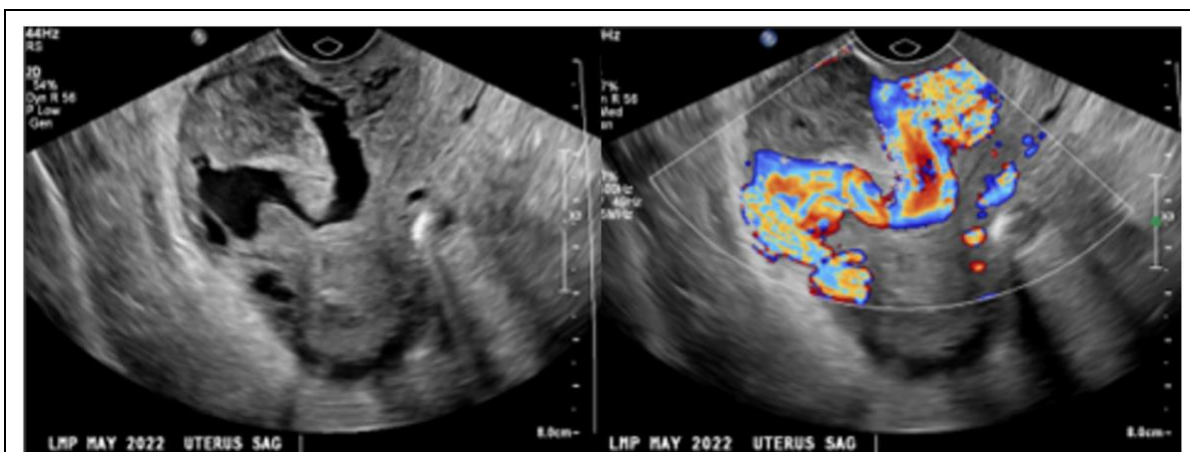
Ultrasound revealing a large anterior lower uterine mass with a transversing dilated vessel (1.7cm) concerning for a large vascular malformation.
